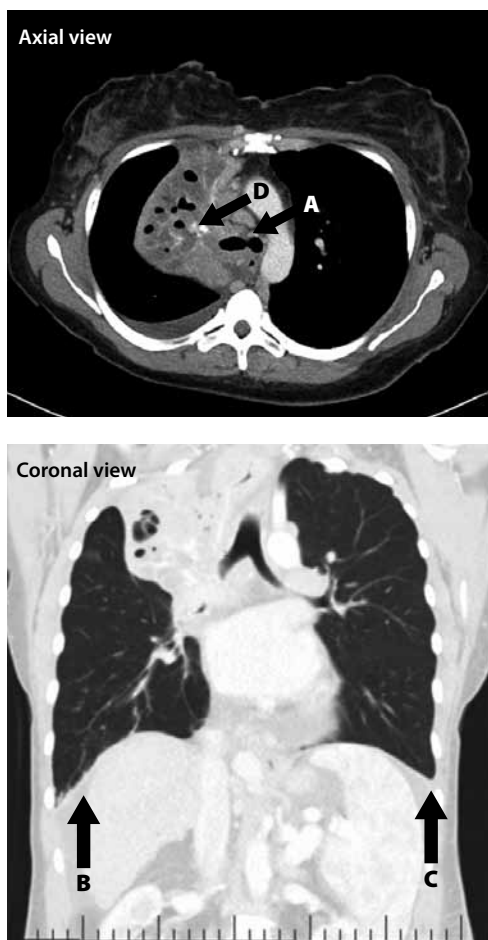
CT images show mass-like area of consolidation involving the entire right upper lobe. Central lucencies indicate multiple locules consistent with cavitation. Both coronal and axial views show that the right upper lobe bronchus is completely obstructed. Right-sided paratracheal lymph nodes (arrow A) can be seen. A small right-sided pleural effusion (arrow B), a minimal left-sided pleural effusion (arrow C), and calcification (arrow D) can also be seen.
